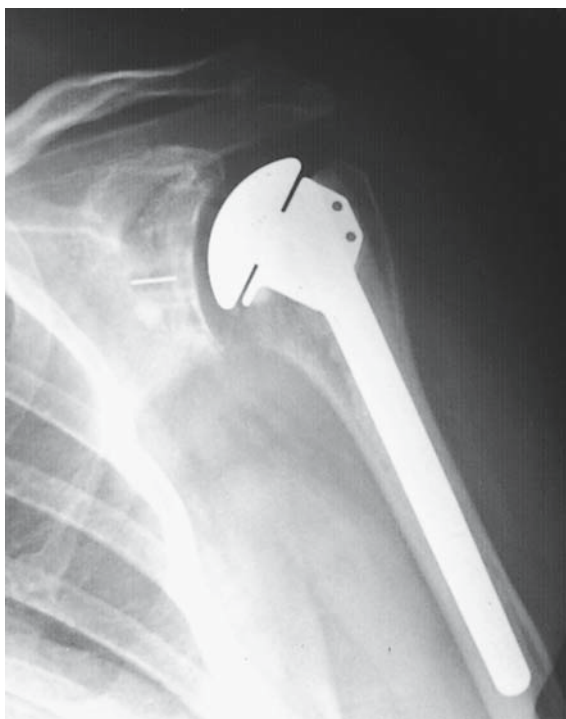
A total shoulder arthroplasty is demonstrated in this true AP X-ray of the glenohumeral joint. The metallic humeral component is cemented into the proximal humerus. The pegged glenoid component is cemented into the glenoid and is represented by the reproduction of the joint space. The central peg of the polyethylene glenoid component is identified by the horizontal radiopaque marker.
